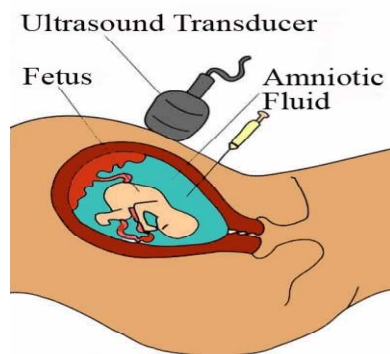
Shows amniocentesis under ultrasound scan directed needle
